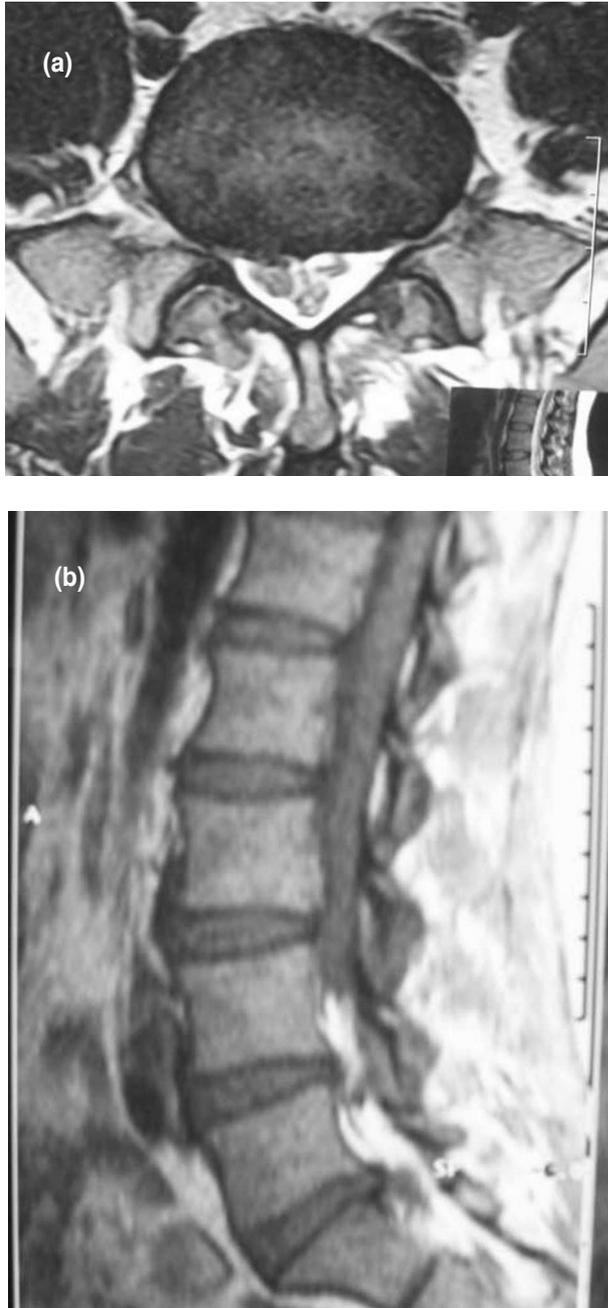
Axial T2 weighted (a) MR image shows enlargement of right S1 root and and sagittal T1 weighted (b) MR image shows extruded disc material.
